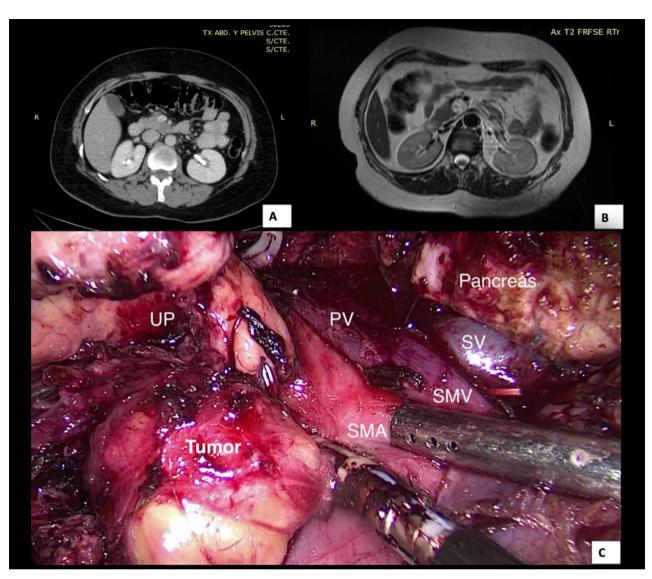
A) TOMOGRAPHY SHOWING A HYPODENSE NODULAR LESION WITH DEFINED EDGES IN A PANCREATIC UNCUS, B) MRI T2 IMAGE OF HYPERINTENSE CHARACTERISTICS WITH HYPOINTEN-SE AREAS INSIDE IS VISUALIZED, C) TUMOR IN CONTACT WITH THE MESENTERIC VESSELS.
